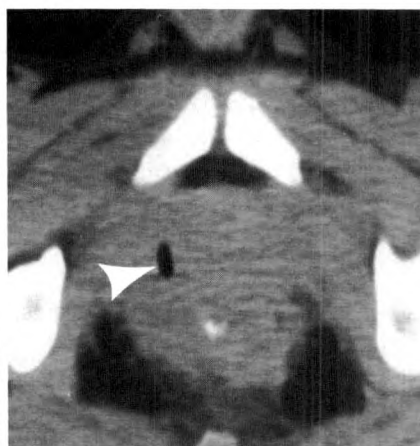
28-year-old man with pelvic pain. Clinical impression was of possible pelvic abscess. CT shows periprostatic abscess with perirectal fistula on right side. Medical therapy was stopped and surgery was performed with drainage of periprostatic abscess.
